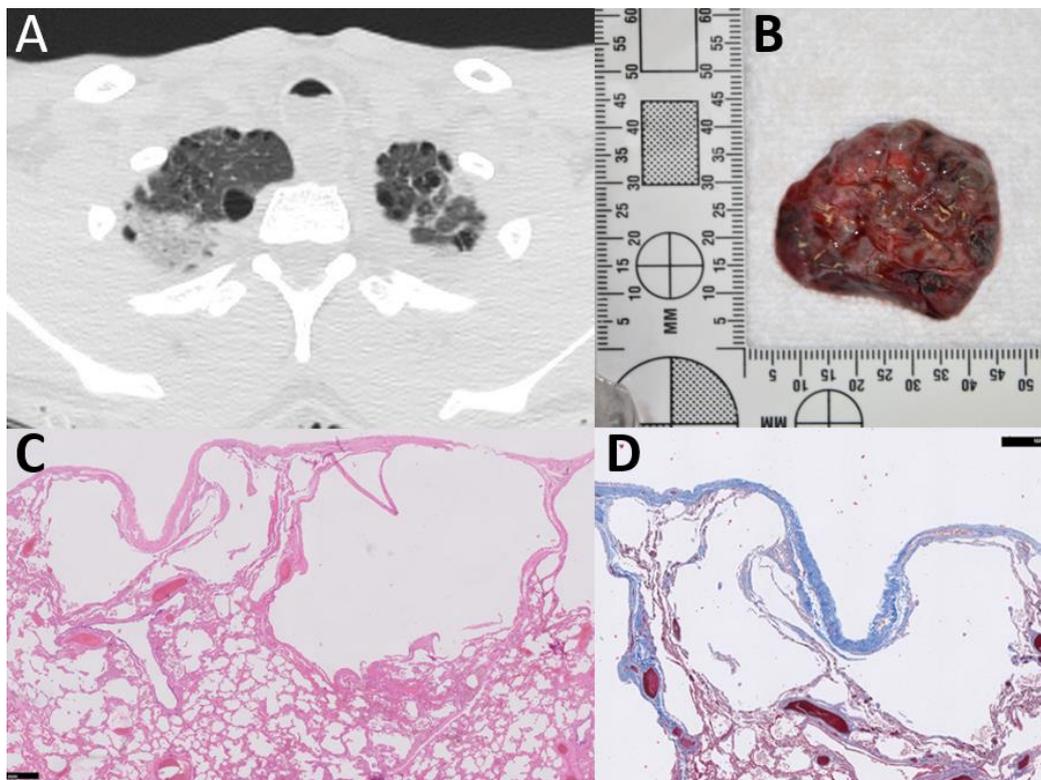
A Post-mortem CT image of the chest in lung window, demonstrating apical lung emphysema (axial view).
